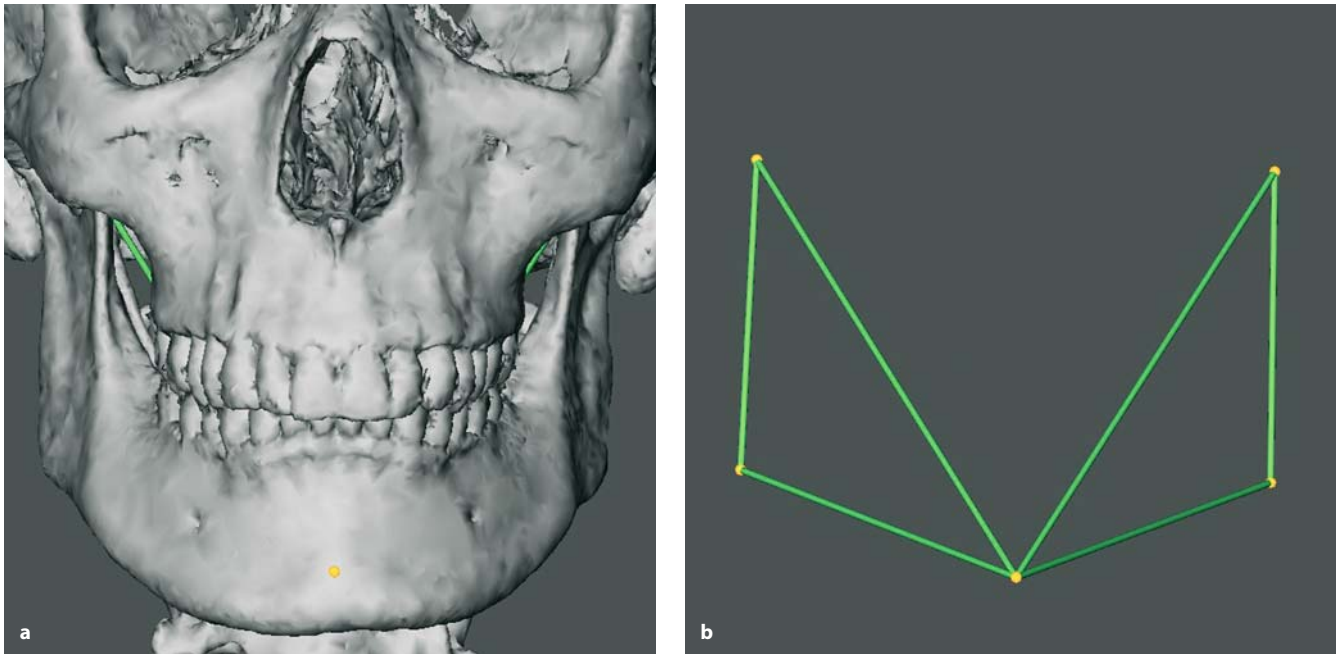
a, b. Right and left mandibular vertical ramus, body and total mandibular length (3-D CT, hard tissues, patient K.C.)
